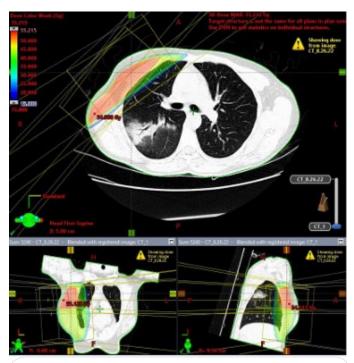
CT chest without contrast, 7 months post-RT: "New opacity in the superior right lower lobe with interval resolution of basilar right lower lobe opacity. In this patient with history of radiation therapy and lack of aspiration risk factors, migratory parenchymal opacities are favored to represent radiation induced organizing pneumonia."
